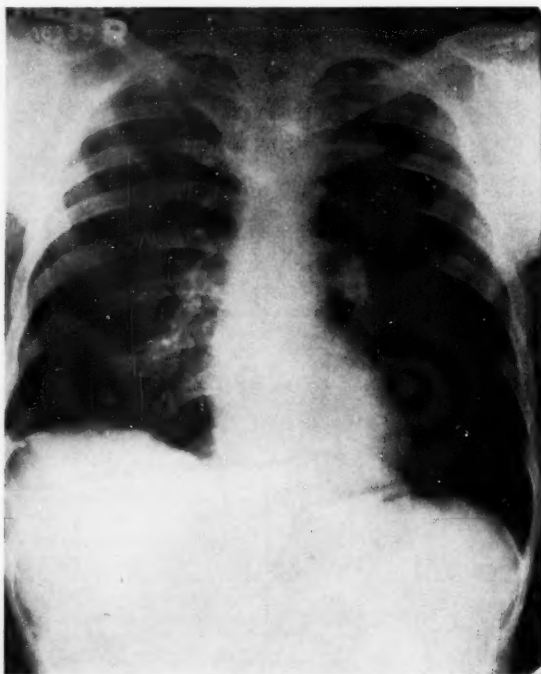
Chest x-ray of Case 3 (E. L. S.) on 60th hospital day showing elevation of right diaphragm.
